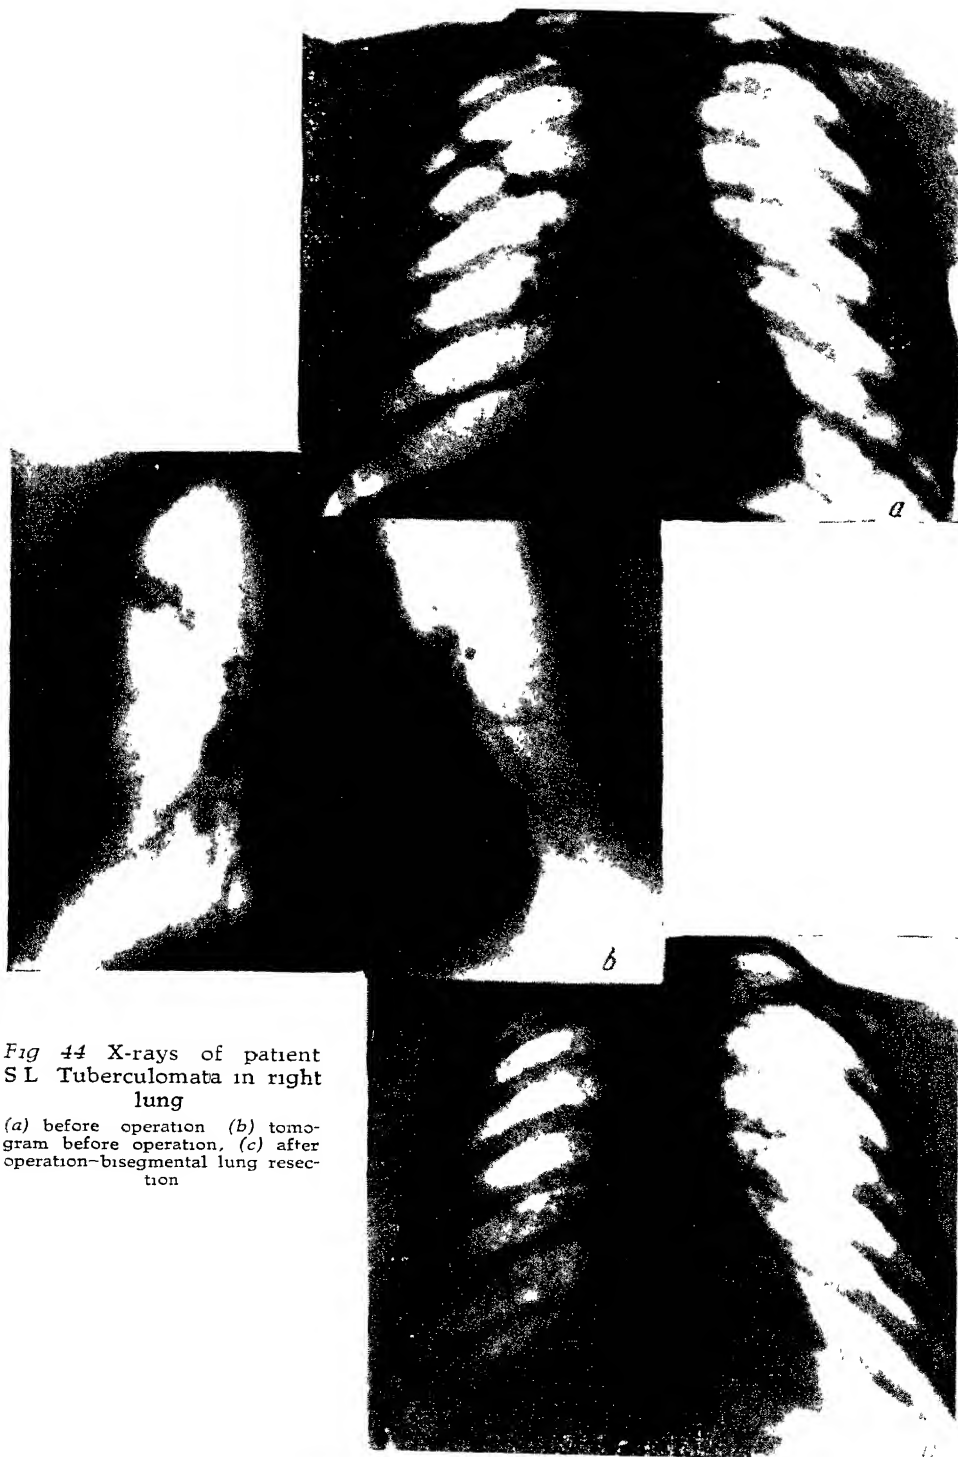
X-rays of patient
